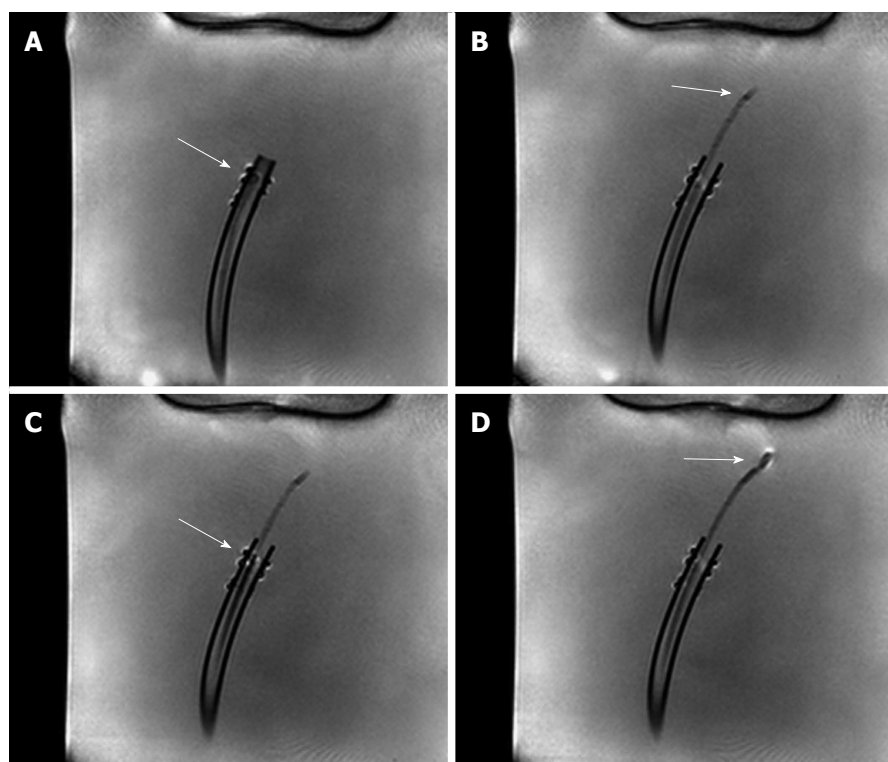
Real-time magnetic resonance imaging image frames with closed (A) and opened (B) cutter.
